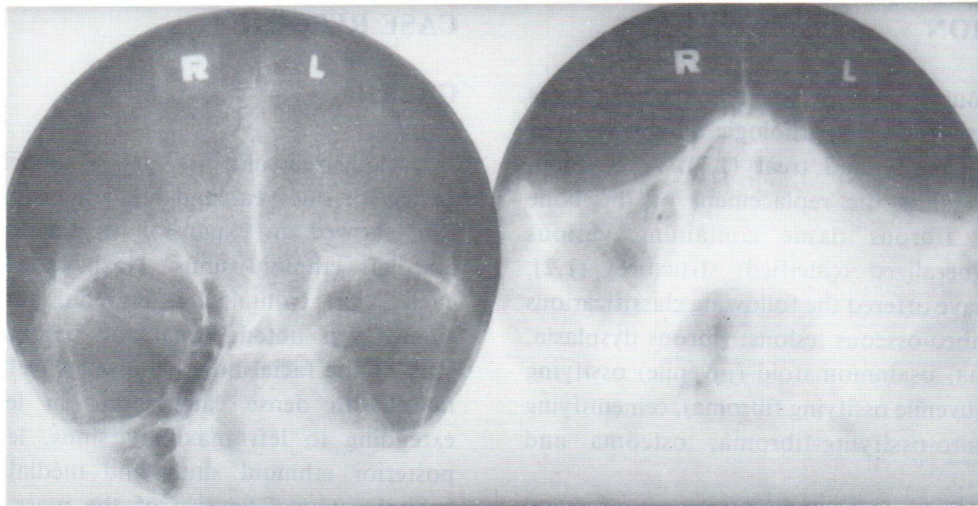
Case 1. Plain film of the paranasal sinuses showed an expansion of the left nasal cavity and left ethmoid sinus with haziness. Left maxillary sinus was not expanded but cloudy. Disappearance of the medial left orbital wall was noted.
